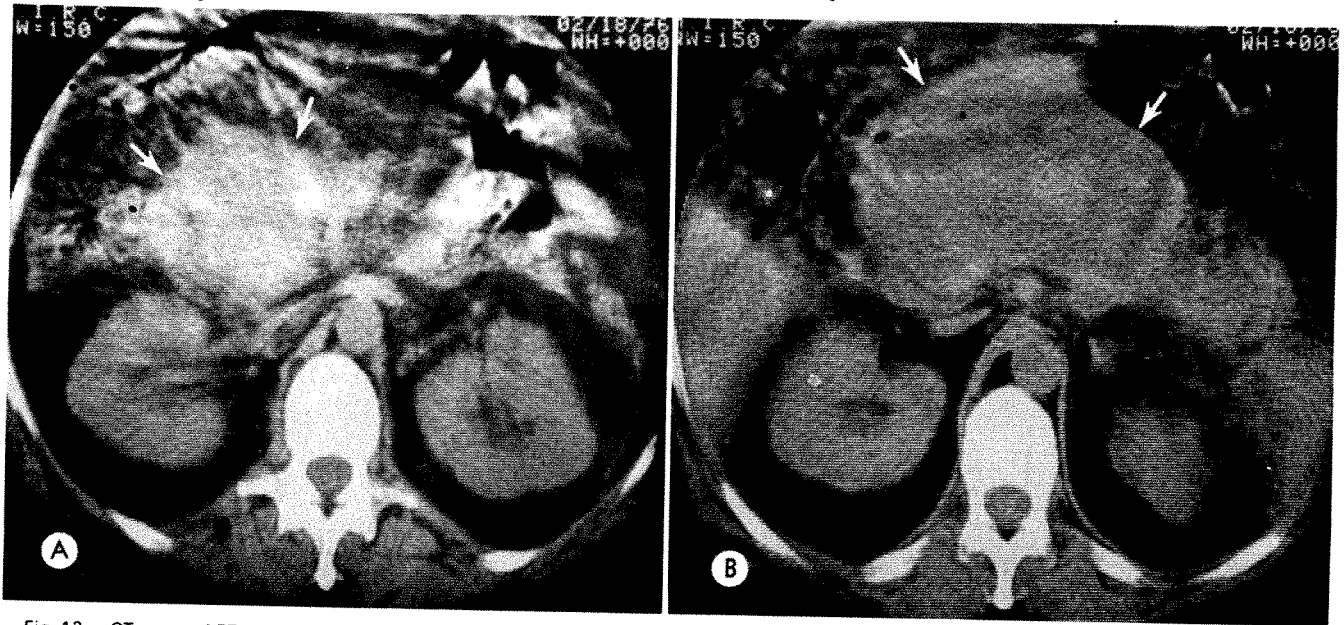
CT scans of 57-year-old man with severe upper abdominal pain, mild hypotension, and markedly elevated serum amylase. A, Massive enlargement of pancreatic head (arrows); B, similar enlargement of pancreatic body (arrows). Marked enlargement of tail seen on higher level scans. Postmortem examination disclosed severe acute hemorrhagic pancreatitis.
